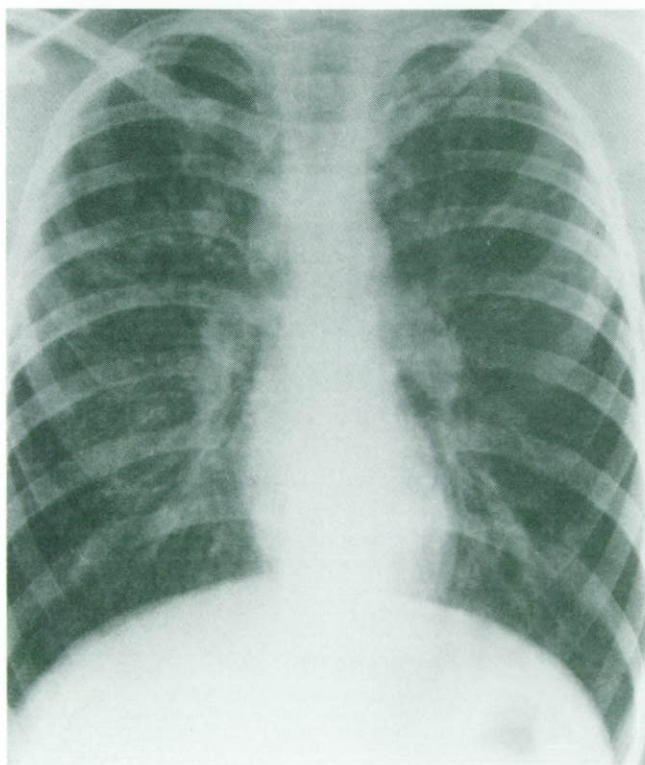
Chest radiograph from a patient with cystic fibrosis; the typical appearances resulting from bronchiectasis and inflammatory change are shown.
